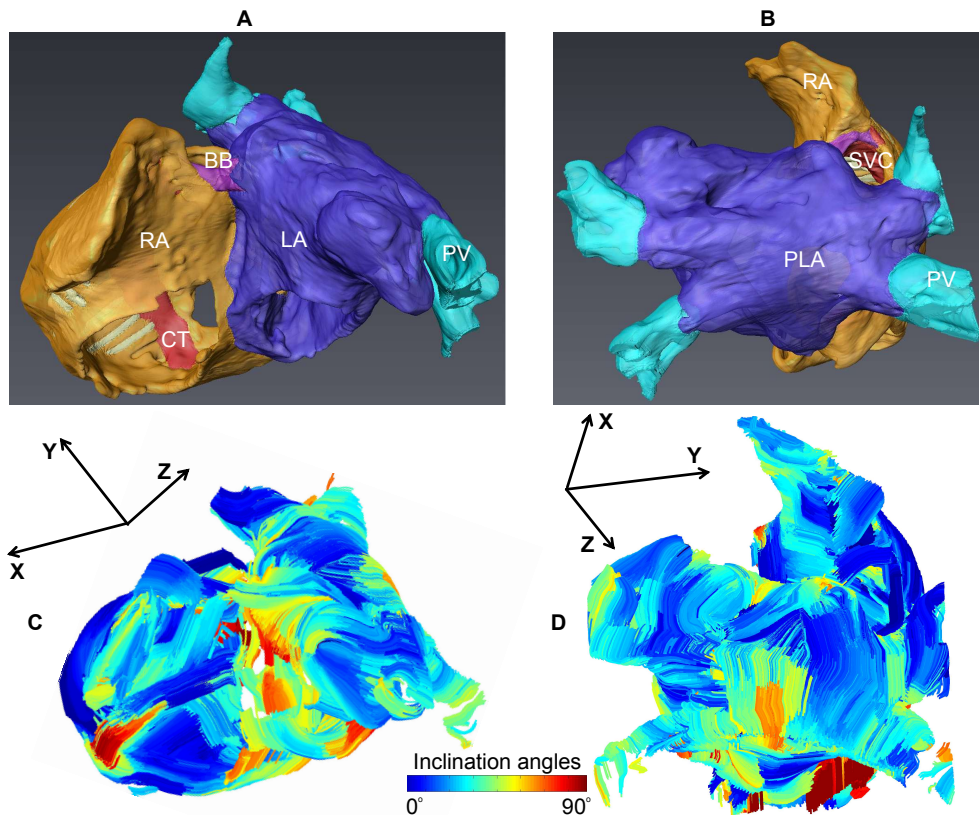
Anatomical structure and intramural myofiber orientation of the human atria. The RA, LA, BB, PVs, PLA, SVC and CT are displayed from an anterior and posterior view in (A) and (B) respectively. Atrial intramural myofiber orientation was displayed in (C) and (D), colour bar represents absolute inclination angle with $\alpha = 0^\circ$ parallel to the X-Y plane and $\alpha = 90^\circ$ corresponding to the Z axis.
